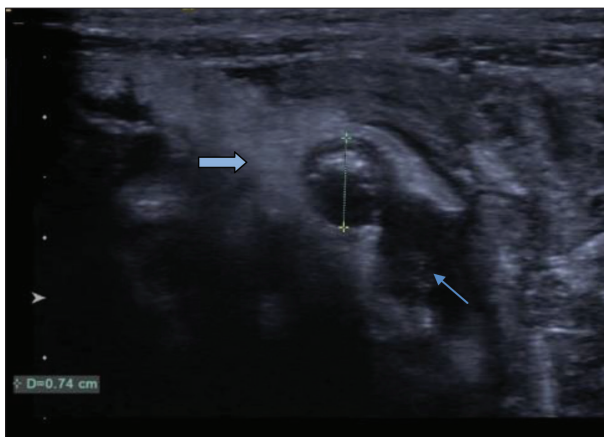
Grayscale axial ultrasonography images of the right lower quadrant in a five-year-old girl with a one-day history of abdominal pain shows a 7.4 mm in diameter noncompressible appendix with hyperchoic periappendiceal fat (bold arrow), wall thickening, and periappendiceal free fluid (thin arrow); complicated (perforated) appendicitis was found at appendectomy
